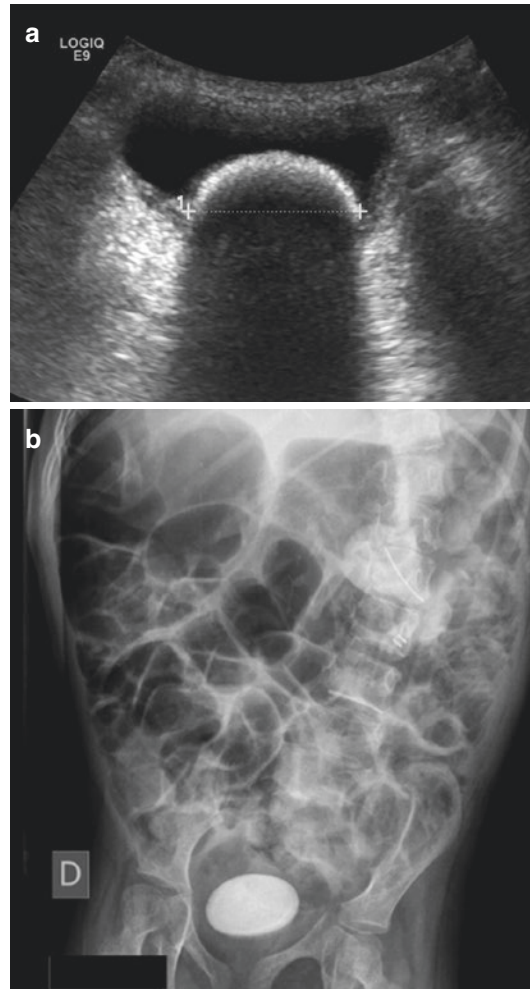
Vesical lithiasis—case of 5-year-old disabled girl. (a) US demonstrating a large intravesical lithiasis (between the crosses) with acoustic shadowing. (b) Plain radiograph confirms the presence of a calcified lithiasis
